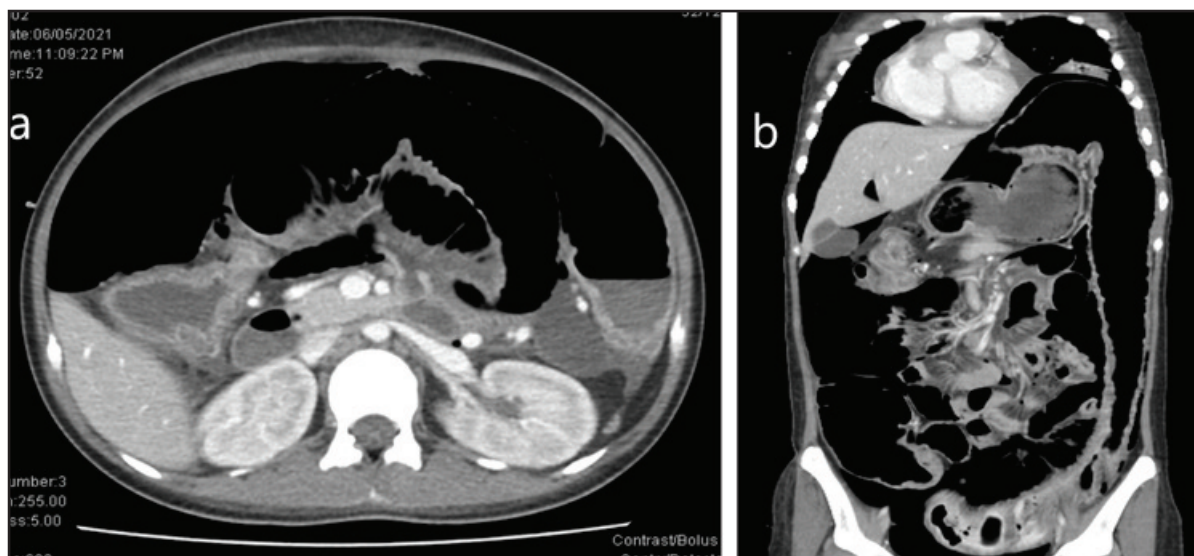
Contrast-enhanced CT scan. (a) axial view and (b) coronal view of the abdomen revealing gross pneumoperitoneum suggestive of bowel perforation with tension pneumoperitoneum.
